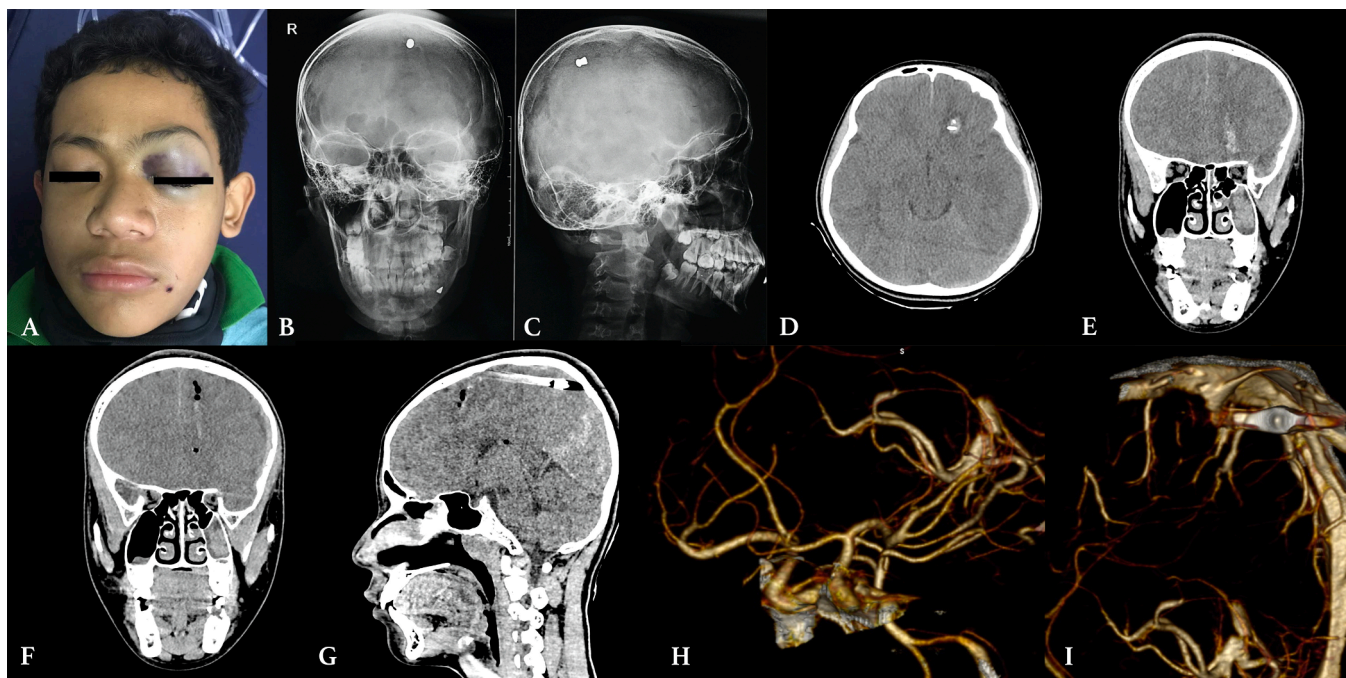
Clinical findings showed palpebral edema and hematoma due to the bullet penetrated the orbital cavity before entering the intracranial space. Entry wound was seen as a clean round shaped on the left buccal area (a). Radiological studies showed foreign body in the intracranial space, cranial x-ray showed radiopaque bullet in the parietal region (b-c). Intracerebral and thin subdural hematoma was seen on the frontal and frontotemporoparietal region (d-e) Intracranial lesion was seen resulting from the bullet trajectory along its pathway. The bullet went through the roof of maxillary sinus and orbital roof showing as fracture in bone window CT (f-g). CT angiography did not show vascular disruption. (b-c) the bullet was not in contact with major blood vessels (h-i).
